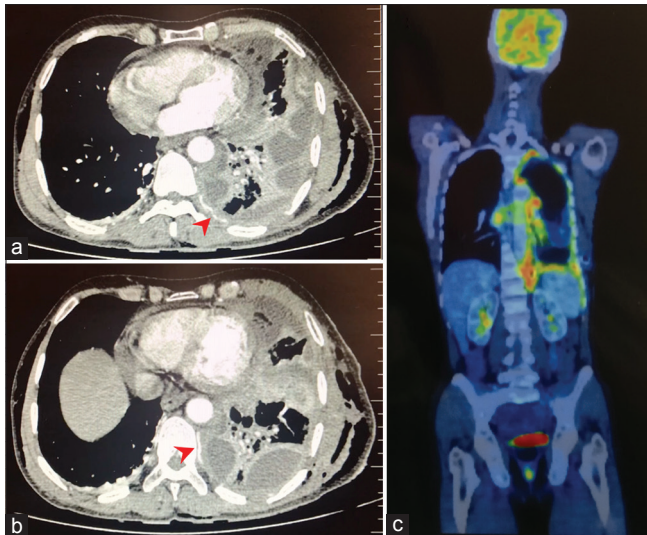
(a and b) Contrast computed tomography chest showing circumferentially thickened pleura encasing the intercostal arteries (arrowheads) – pleural sandwich sign; (c) whole-body positron emission tomography-computed tomography scan showing metabolically active diffuse left pleural nodular thickening and fluorodeoxyglucose-avid left hilar, tracheobronchial, prearcinal, prevascular, and subcarinal nodes
